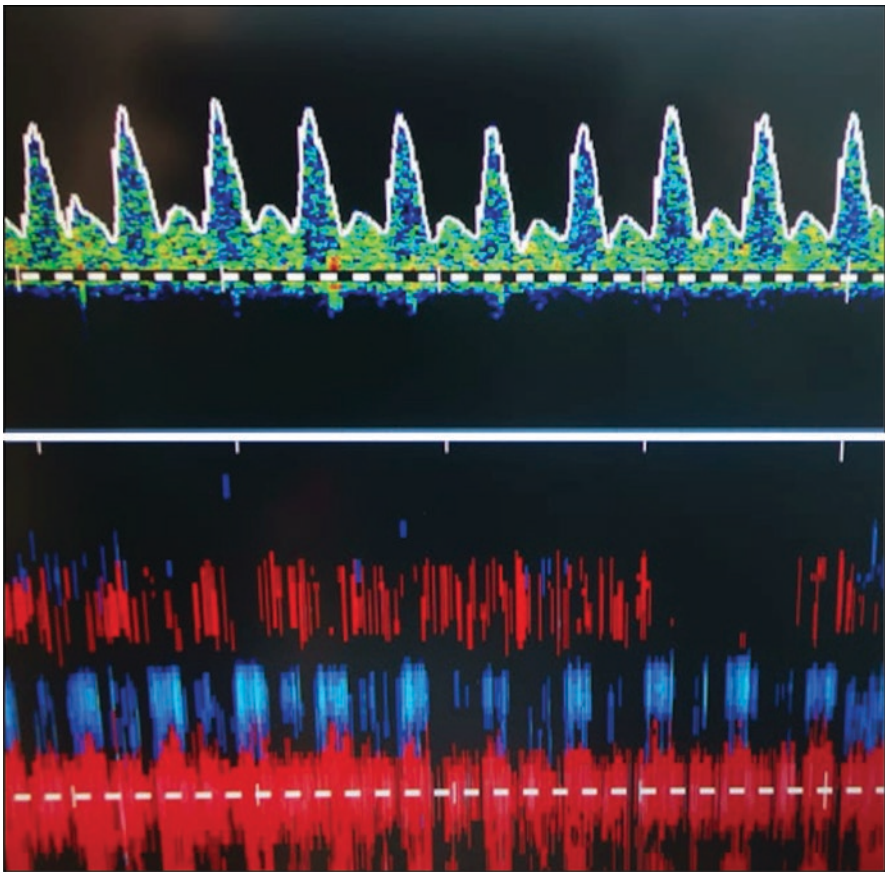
Sonogram: High resistance pattern (MCA)
